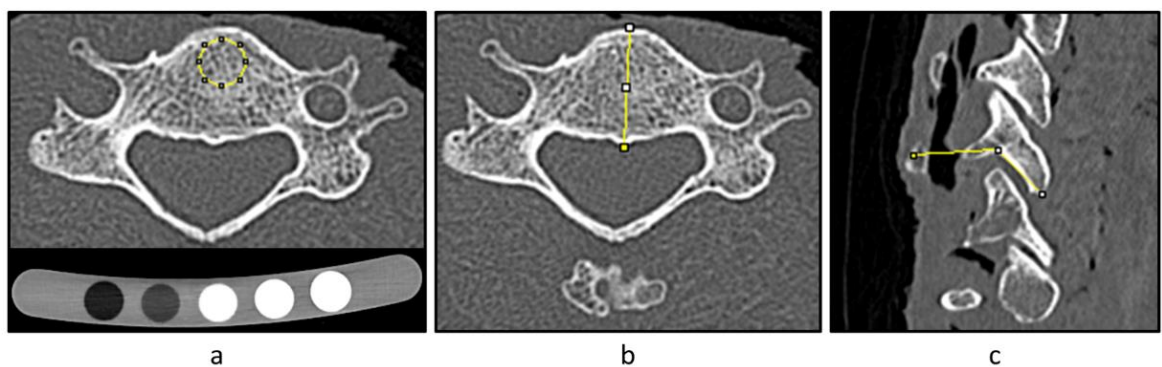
Measurements obtained from high-resolution computed tomography images: a) average volumetric bone mineral density; b) vertebral body depth; and, c) sagittal facet angle.
